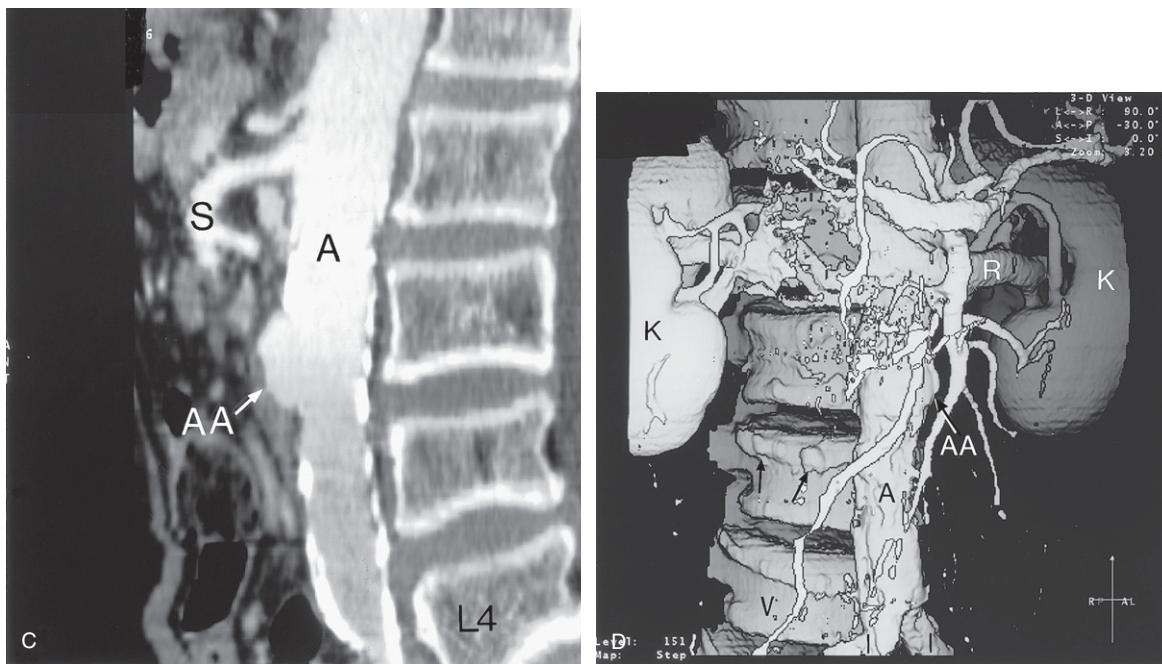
Cont'd (C) CT 3-D reconstruction image showing the infra-renal small abdominal aortic aneurysm (AA), abdominal aorta (A) and superior mesenteric artery (S). L4 = fourth lumbar vertebral body. (D) CT 3-D reconstruction image showing the kidneys (K), renal artery (R), abdominal aorta (A), small aneurysm of the abdominal aorta (AA) and common iliac arteries (I). V = vertebral body of the fourth lumbar vertebra. Black arrows indicate osteoarthrotic lipping along the superior margin of the L3 vertebral body; lipping can also be seen at some of the other vertebral body levels adjacent to the intervertebral disc spaces.
